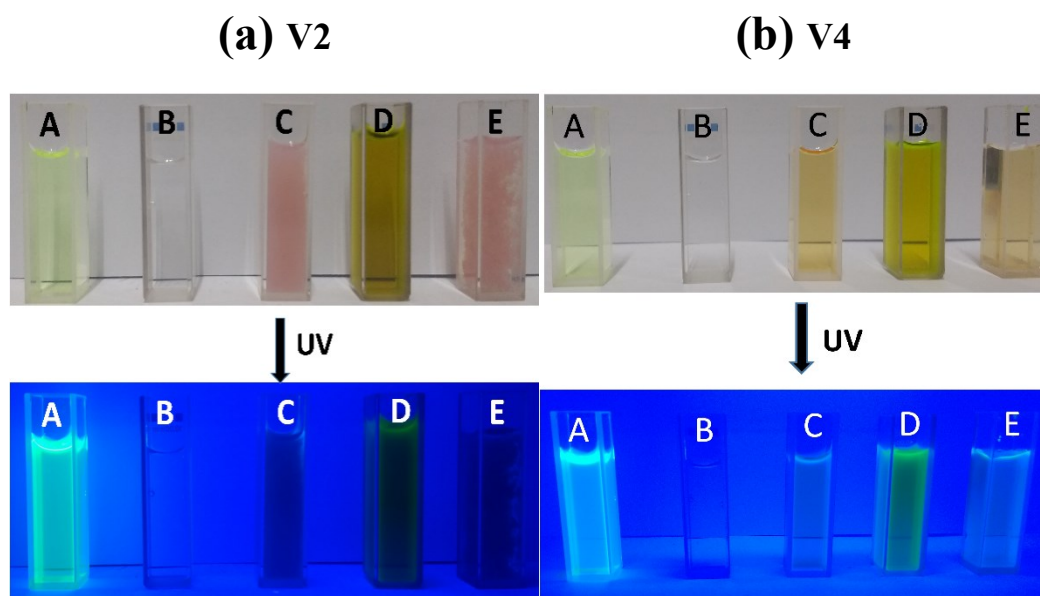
(a) Photographs of [V2-Pyr] and [V4-Pyr] CT aggregates in aqueous medium. A: Pyranine; B: V2; C: V2-Pyranine complex; D: V2-Pyranine complex + 20 μ L of 1M NaOH; E: D + 20 μ L of 1M HCl; (b)A: Pyranine; B: V4; C: V4-Pyranine complex; D: V4-Pyranine complex + 20 μ L of 1M NaOH; E: D + 20 μ L of 1M HCl; (*Top* – Photographs of aqueous solutions and suspensions taken under room light; *Bottom* – Photographs of aqueous solutions and suspensions taken under UV irradiation at 365 nm)
